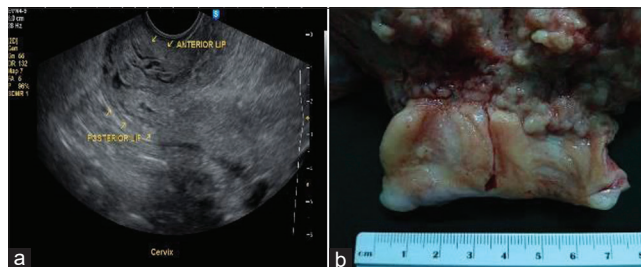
Ultrasound and gross appearance of cervical stromal invasion on ultrasound (a) and gross (b) appearance
